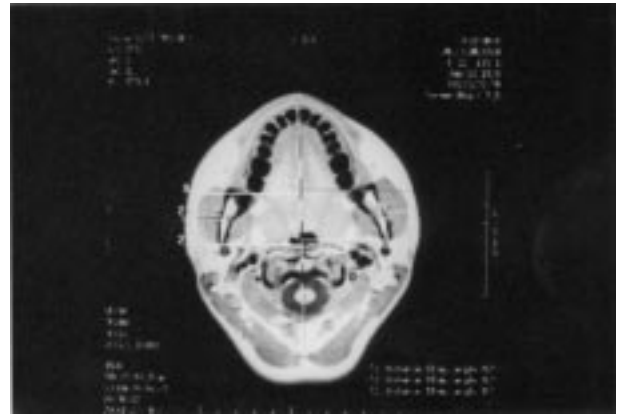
Sagittal MRI scan taken through the cervical margins of the mandibular teeth pre-operatively
